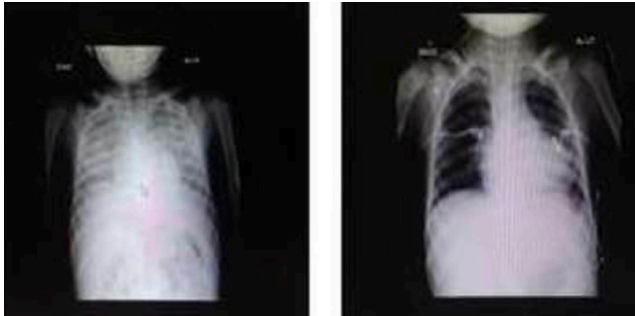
Chest X-ray before (left) and after (right) extracorporeal life support (ECLS) and balloon atrial septostomy (BAS) management.
